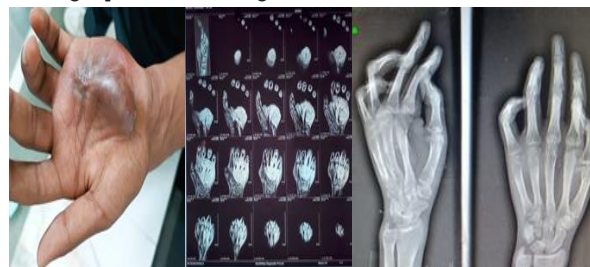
Ill-defined, tense swelling, MRI hand shows T1 iso-hypointense, T2 hyperintense heterogeneous mass, AP and oblique radiographs of the right hand showing an aggressive soft tissue mass with osteolytic destruction of the fifth metacarpal and phalanges.
